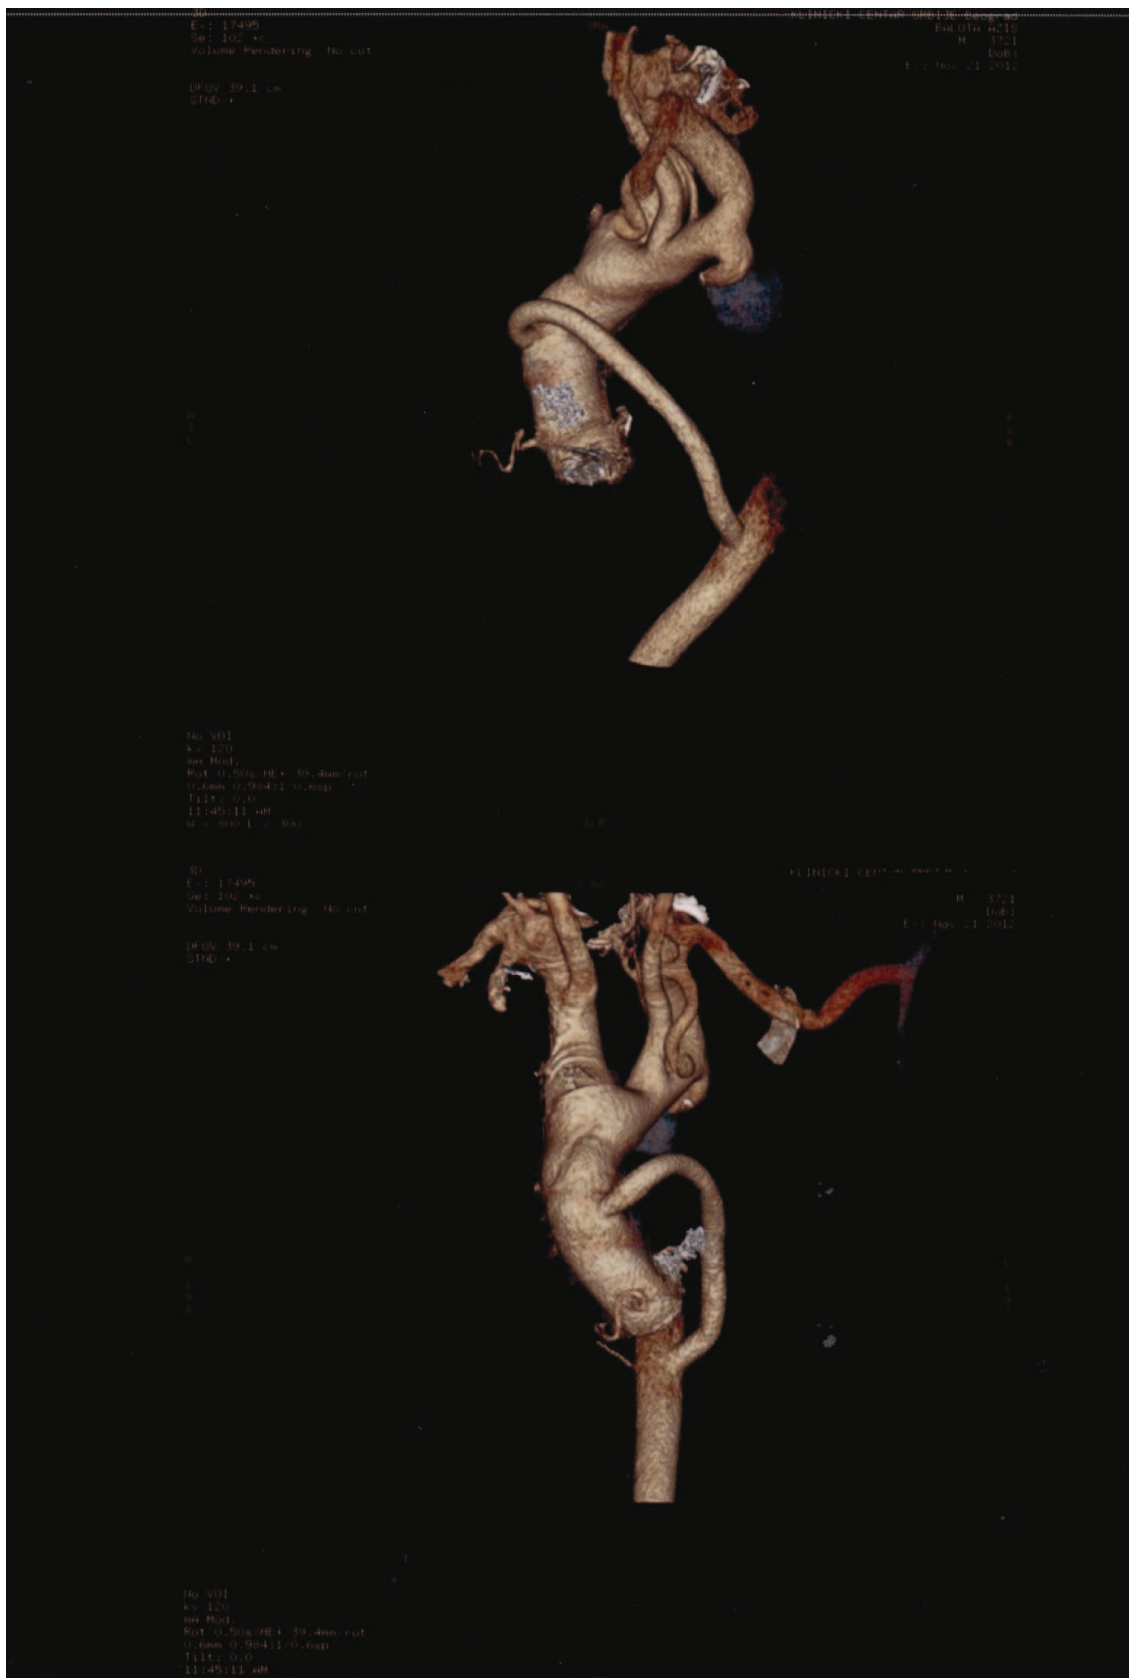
Postsurgical multislice computed tomography showing repaired aneurysm with interposition of Dacron graft. Repaired coarctation with extraanatomic bypass (ascending to descending aorta).
